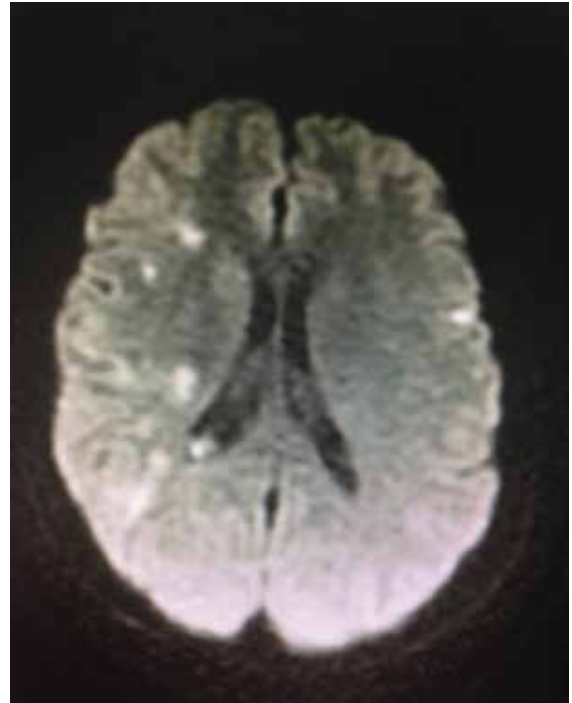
MRI brain DWI sequence showing bilateral infarcts.
